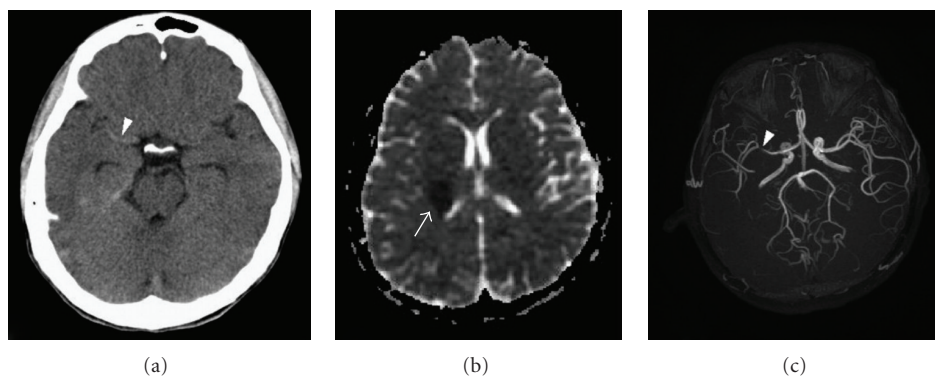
A 15-year-old boy suddenly experienced acute right-sided headache and dizziness followed by drowsy consciousness and left-sided weakness after practicing backward somersaults. Nonenhanced CT image of the brain (a) showed increased attenuation at the M1 segment of the right MCA (white arrowhead). Apparent diffusion map of the brain (b) delineated a 2.4-cm low-signal area in the posterior limb of the right internal capsule, consistent with a hyperacute infarct (arrow). Magnetic resonance angiography of the brain (c) showed focal stenosis of the right MCA with decreased flow and number of distal branches (white arrowhead).
